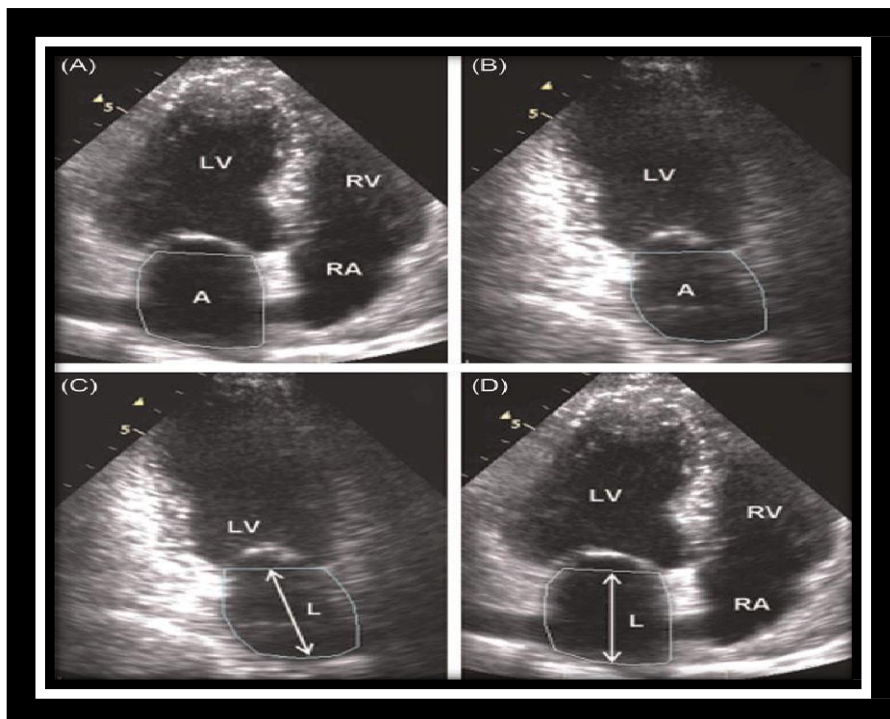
Measurement of left atrial (LA) volume from the biplane area-length method using the apical 4-chamber and apical 2-chamber views at ventricular end systole (maximum LA size). LA inner border, excluding the area under the MV annulus, pulmonary veins, and LA appendage should be taken. A, area; L, length measured from the mitral annular plane to the back wall; LV, left ventricle; RA, right atrium; RV, right ventricle. LA volume  $(0.85 \times A1 \times A2)/L$ . (Courtesy Panupong Jiamsripong et al.)<sup>10</sup>
